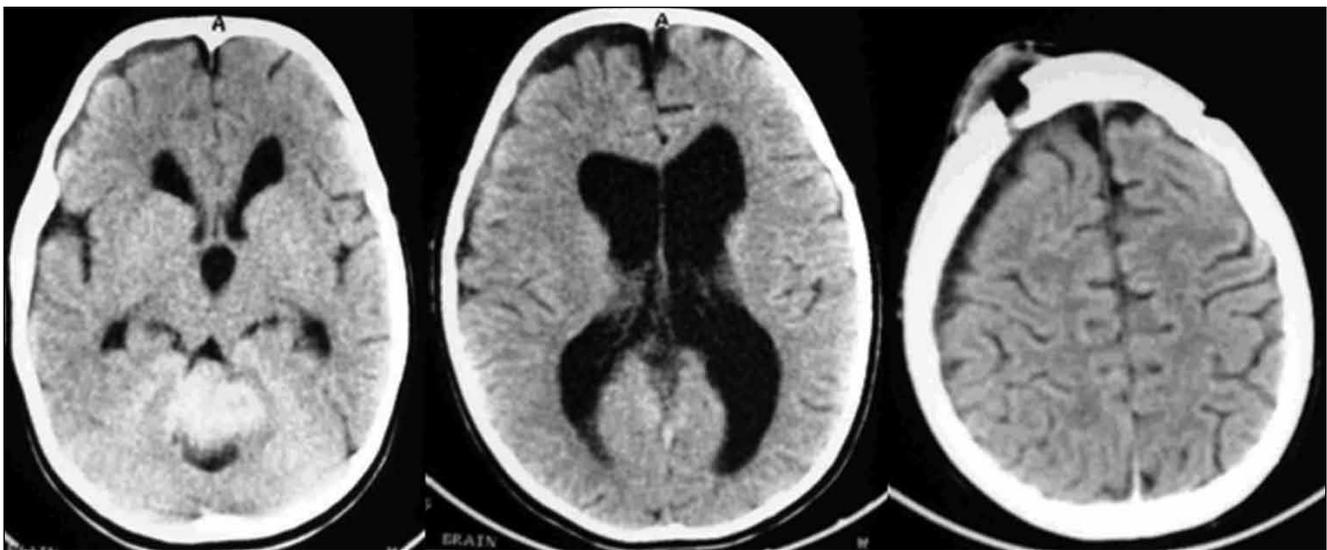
CT with contrast images of case No.3 after undergoing ETV before tumor resection. The subarachnoid spaces are widened and radiological signs of active hydrocephalus are absent.
